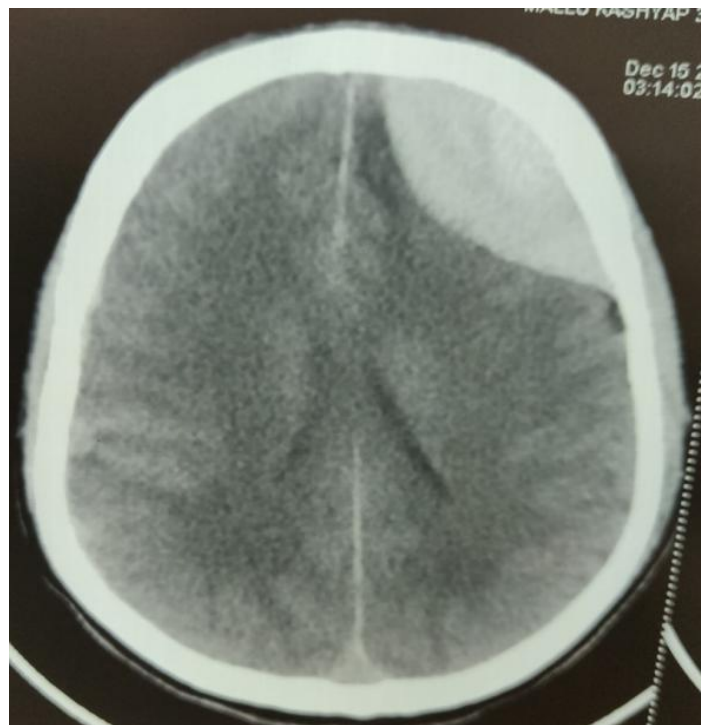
CT Scan of skull showing extradural hematoma. The shape of the hematoma is typically biconvex
